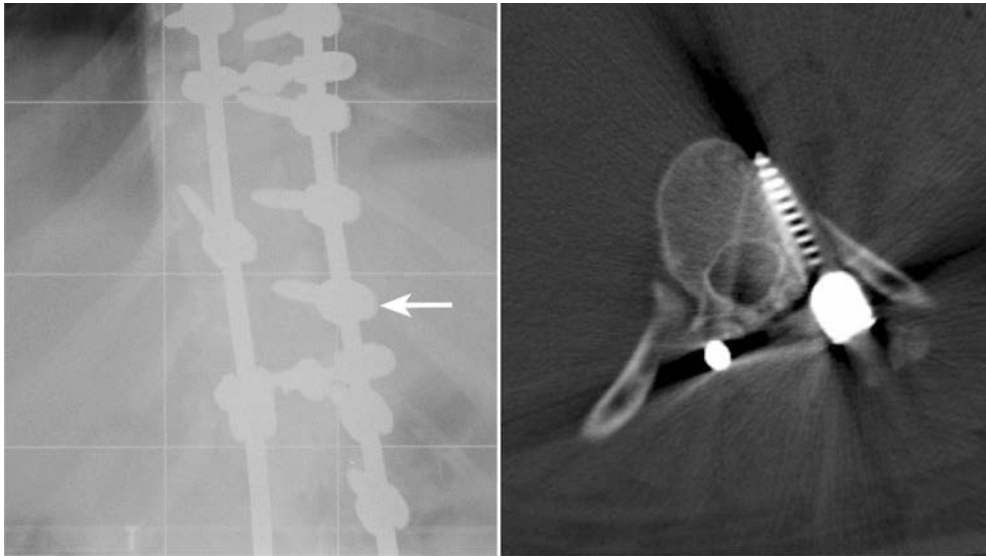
Radiographic film (left) showing a normal screw placement, with the computed tomographic scan (right) showing a lateral misplacement, denoted by the arrow.
